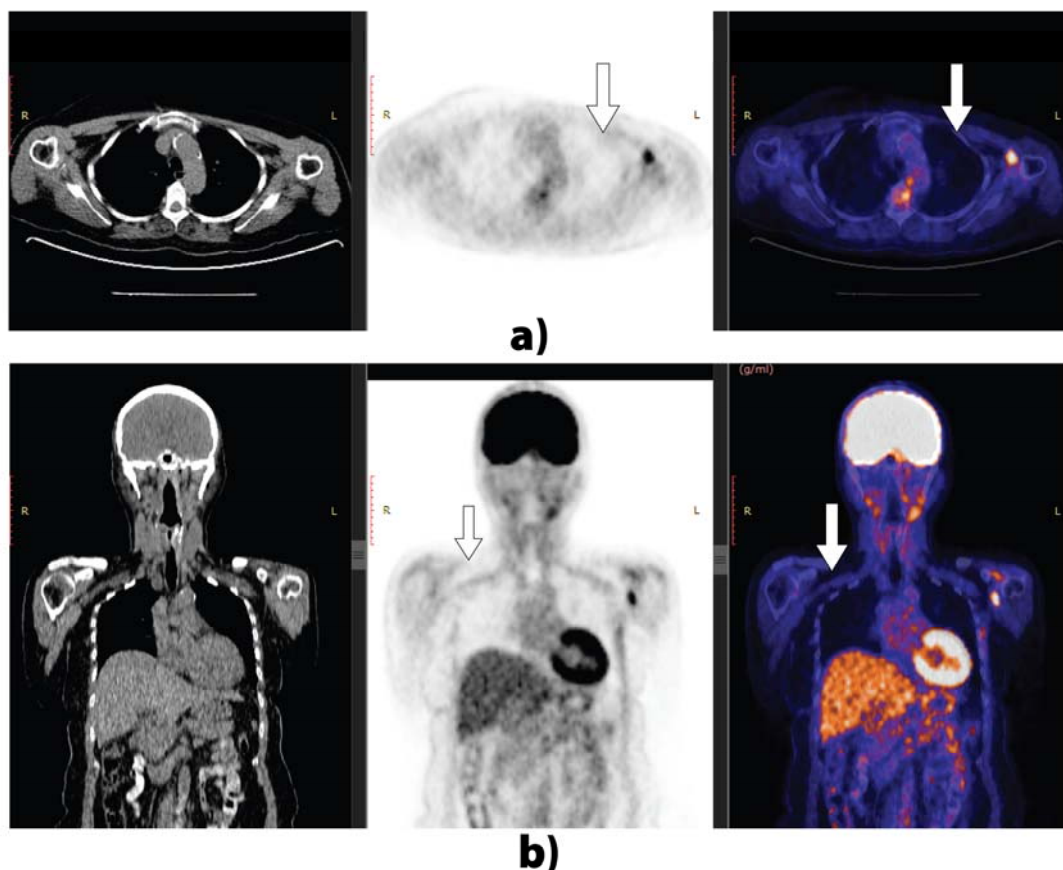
a) A 61-year-old woman with right invasive ductal breast cancer, stage pT1, underwent mastectomy, chemotherapy and radiation followed by tamoxifen and trastuzumab (Herceptin[®]). Transaxial sections (a) and coronal sections (b) detect hypermetabolic lymph node in the left axilla 1.7 cm in size, SUVmax = 10, consistent with axillar involvement.
